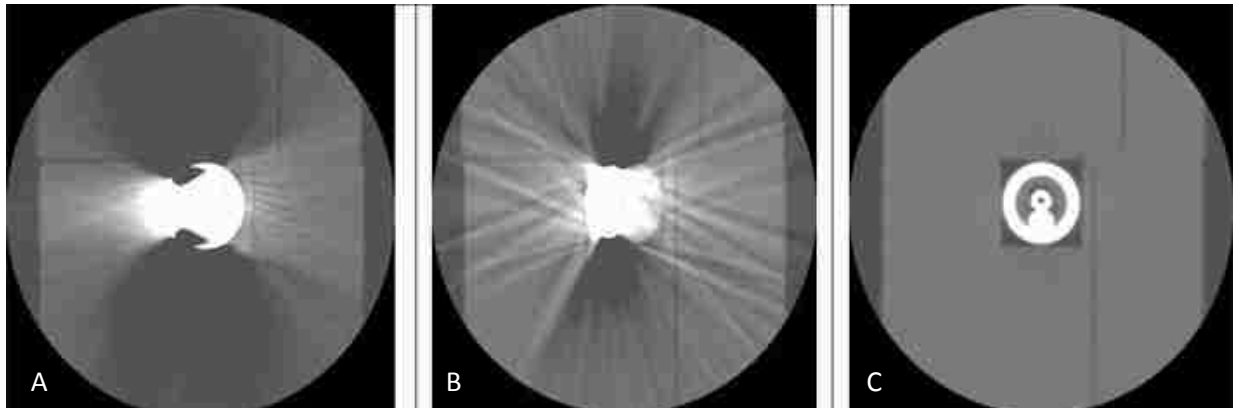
Comparison of reconstructed axial CT slices through the bladders shields of the shielded Fletcher-Suit-Delclos applicator (A), the shielded Fletcher Williamson applicator (B) and Price's A³ applicator (C)
